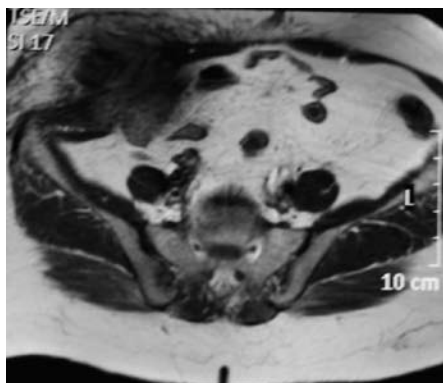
Pre-operative magnetic resonance imaging view of our case.
